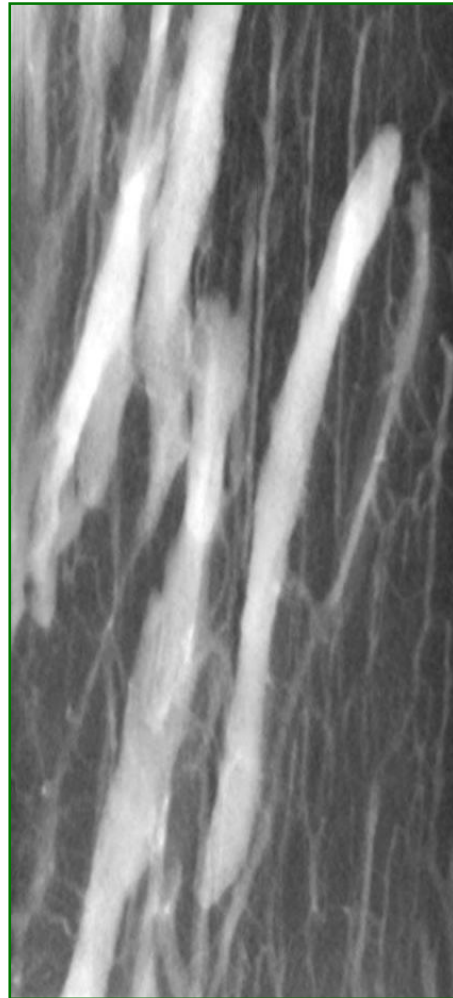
BMU resorption spaces.  $\mu$ -CT image of BMU resorption spaces in human bone (mid femur). Image provided courtesy of D.M.L. Cooper
